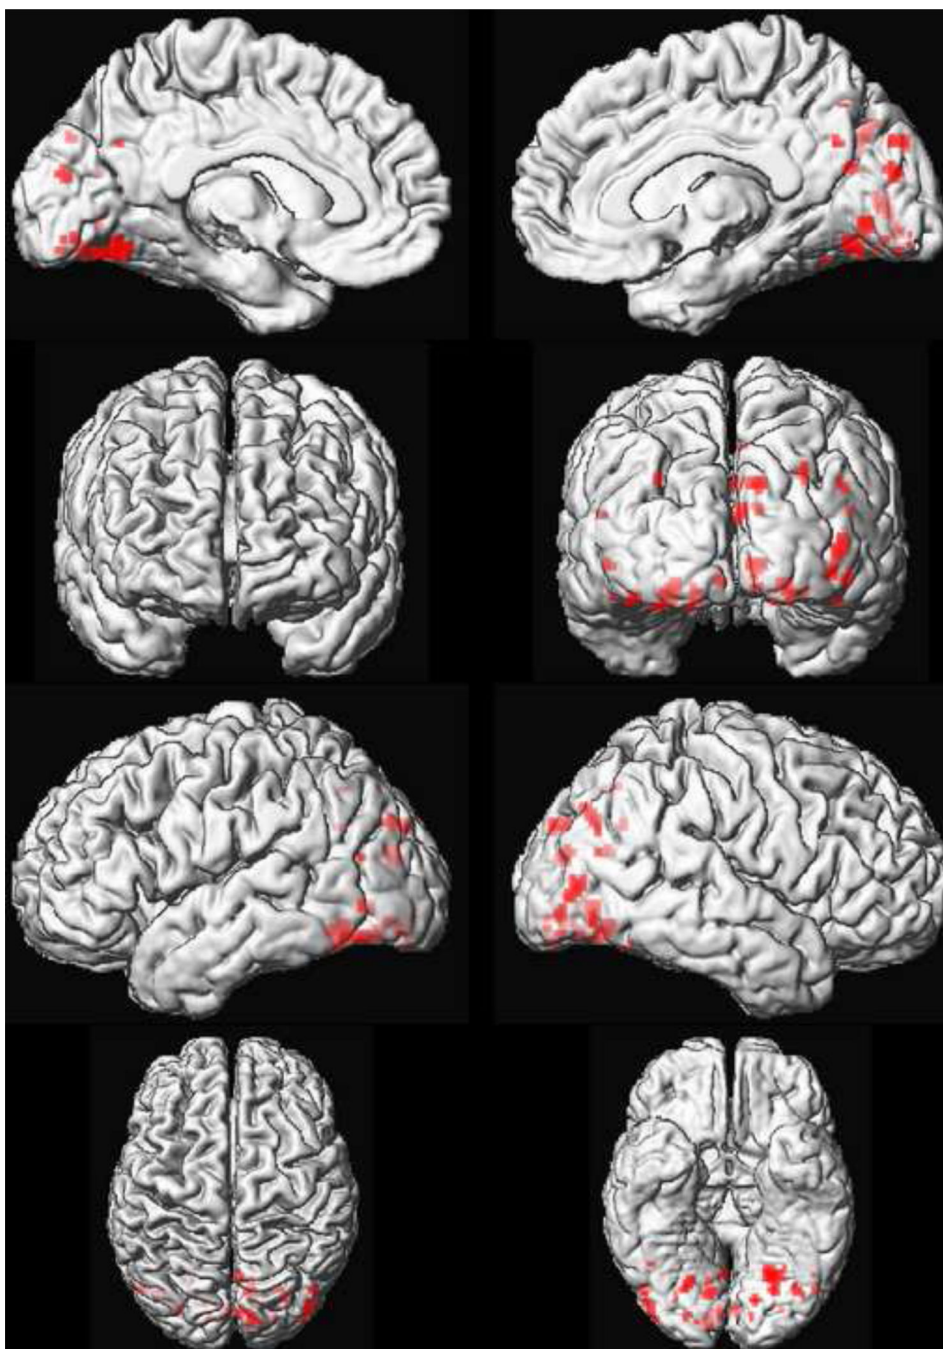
Regional FDG hypometabolism in patients with DLB compared to AD
